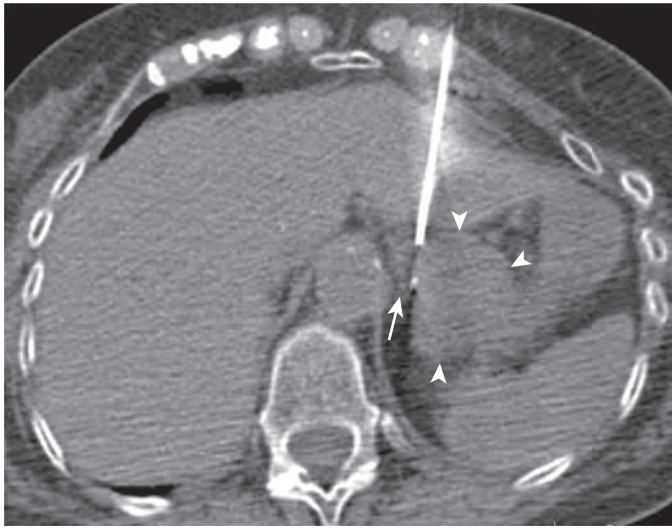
CT scan of a 66-year-old man with lung carcinoma. Axial noncontrast CT of the upper abdomen reveals an enlarged left adrenal gland (arrow) adjacent to the gastric fundus/proximal gastric body (arrowheads). The left adrenal gland was biopsied with a transhepatic approach. The liver tolerates needle transgression well as long as blood vessels are avoided. Fine-needle aspiration revealed metastatic carcinoma. Of note, the patient was initially scanned in the prone and left lateral decubitus positions in the hope of accessing the lesion posteriorly, but the intervening left kidney prevented this approach.
